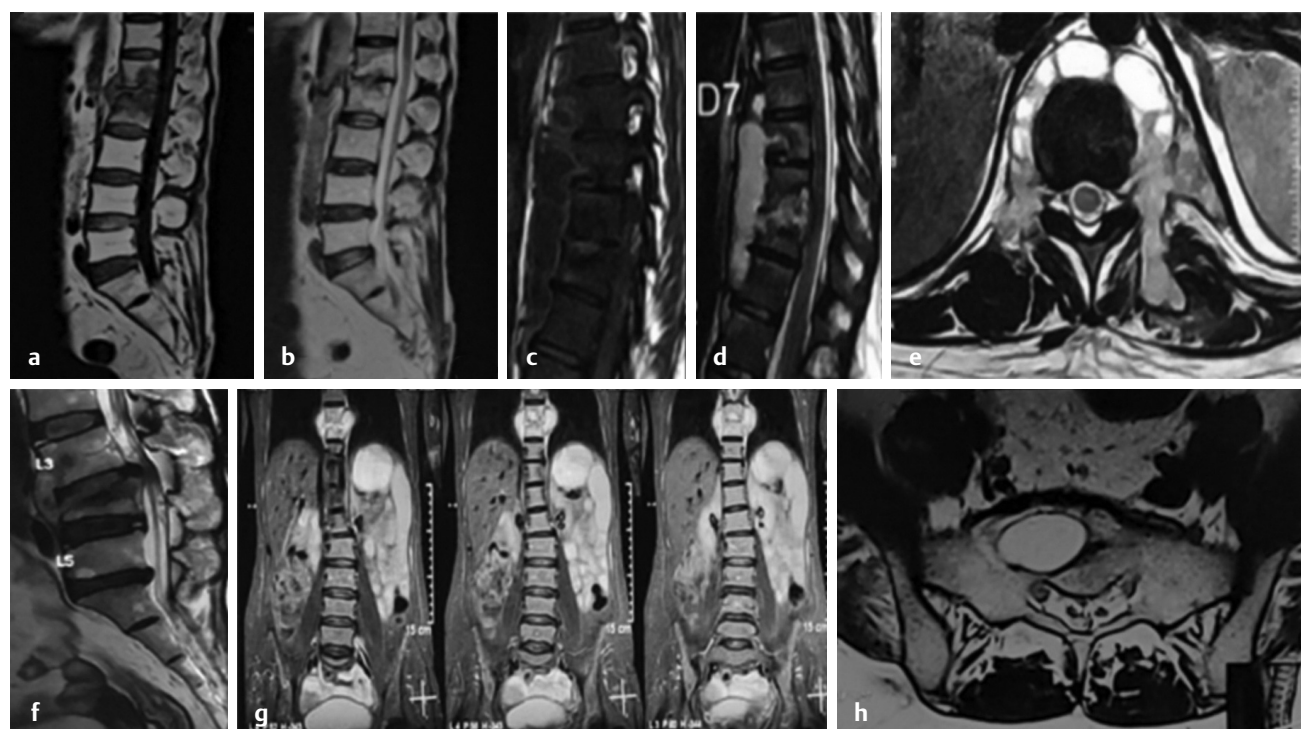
Spinal tuberculosis lesions in various sequences. (a, b) T1-weighted and T2-weighted images showing marrow edema as hypointense and hyperintense lesions, respectively, along with end plate erosions. (c–e) Short tau inversion recovery (STIR) images showing the subligamentous spread of abscess in sagittal and axial sections. (f) Paradiskal lesions with preserved disk space pathognomonic of spinal tuberculosis. (g) Coronal section depicting the extent of paravertebral abscess as hyperintense lesions in T2-weighted images. (h) Intraosseous abscess appearing as hyperintense lesions in the T2-weighted image.
